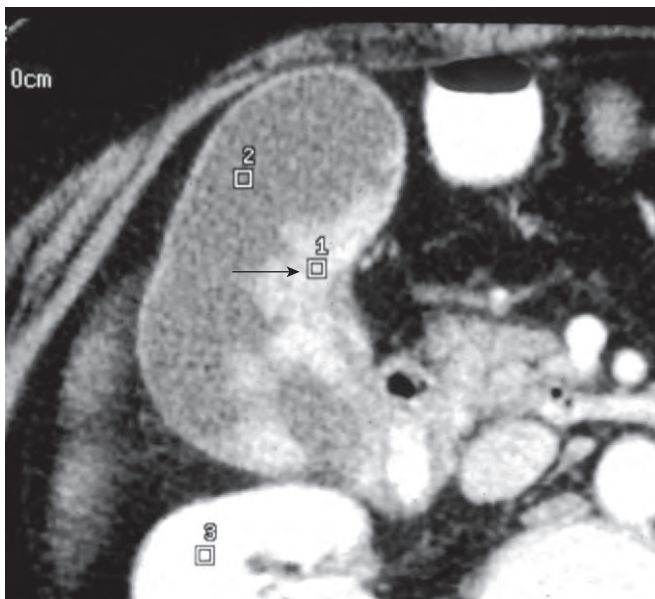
Appearance of gallbladder cancer on CT scan. Note the extensive sessile polypoid lesion within the lumen of the gallbladder wall.
